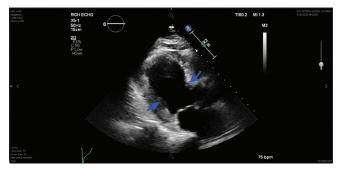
During systole, left ventricle showing apical ballooning/ akinesis in left anterior descending (LAD) territory. The blue arrows signify normally constricting myocardium and the apex seems to be ballooning above it. This is an image of the echocardiogram of the patient.
